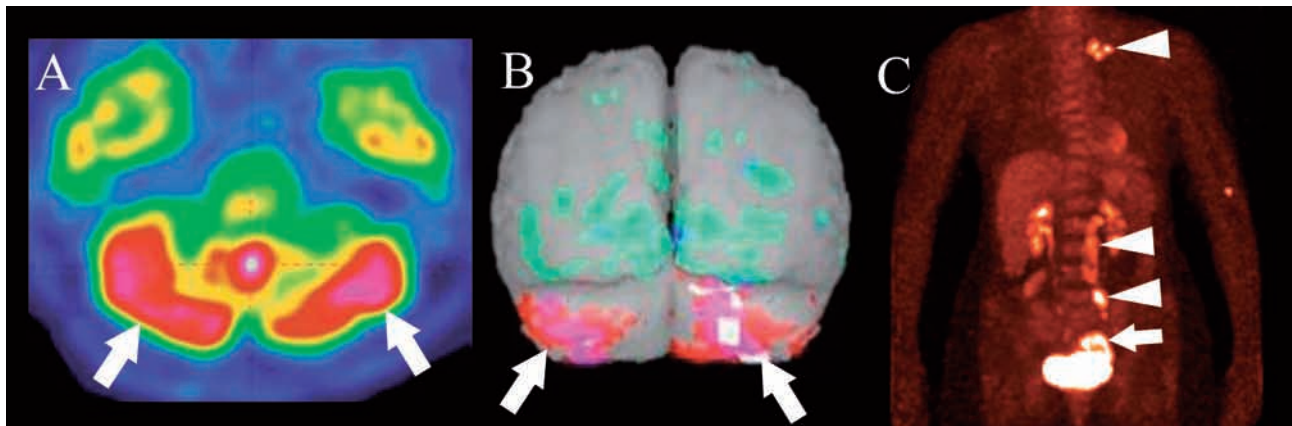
Brain FDG-PET (axial view at the level of cerebellum) showing heterogeneous cerebellar hypermetabolism (A), confirmed when using 3D projection (posterior view) of Z scores comparatively to values from 33 age (mean: 65 yrs) - and sex-matched healthy subjects (grey for normal metabolism; hypermetabolism shown in red for > 2SD, pink for > 3SD, and white for > 4SD) (B). Whole body FDG-PET showed left ovarian (arrow) as well as pelvic, abdominal, and subclavian lymph node (arrowheads) hypermetabolism (C).
